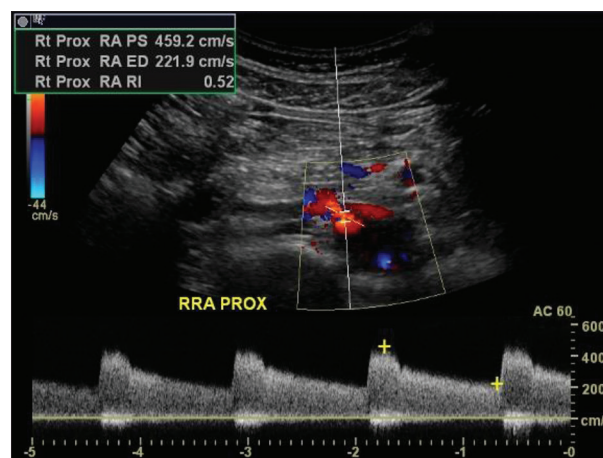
Ultrasound Doppler showing renal artery resistive index of 0.52 suggestive of significant renal artery stenosis
